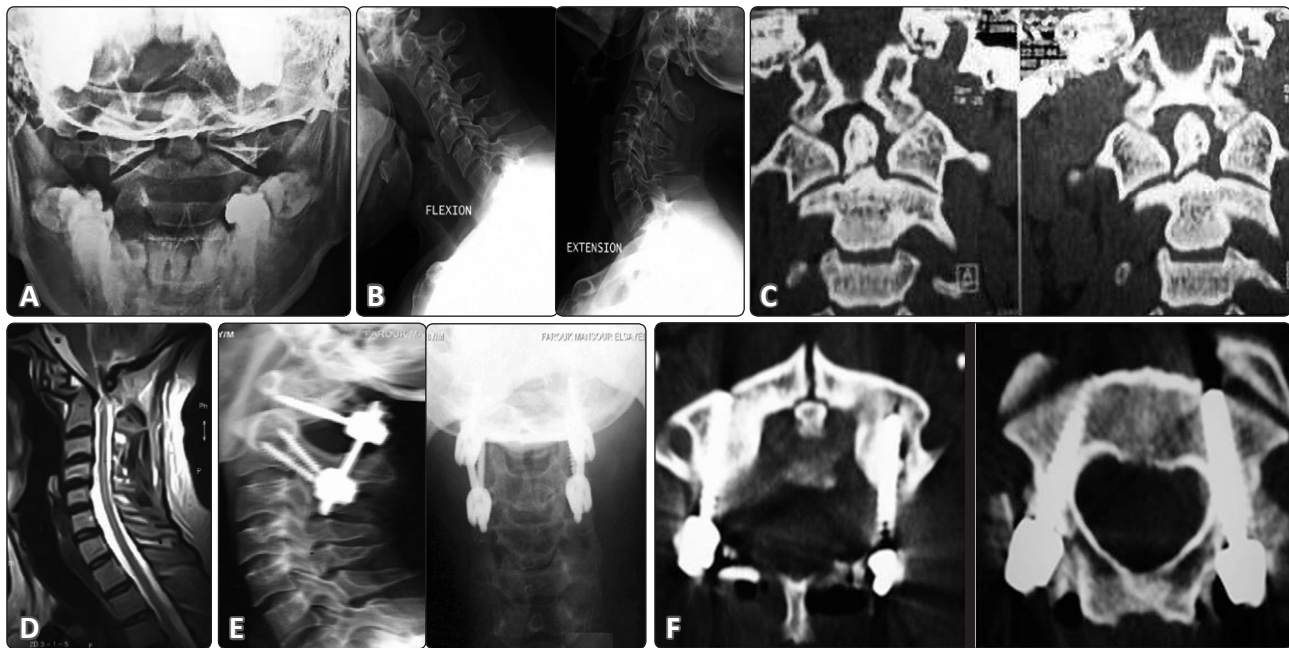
(A) Preoperative X-ray cervical spine open mouth view showing odontoid fracture type II and (B) X-ray flexion and extension films showing atlantoaxial instability. (C) Coronal preoperative CT showing type II odontoid fracture. (D) Preoperative MRI cervical spine sagittal T₂ showing odontoid fracture and atlantoaxial dislocation. (E) Postoperative X-ray cervical spine lateral and A-P views showing reduction and fixation by C1 lateral mass screws and C2 pedicle screw. (F) Postoperative CT scan axial views showing good screws position.
